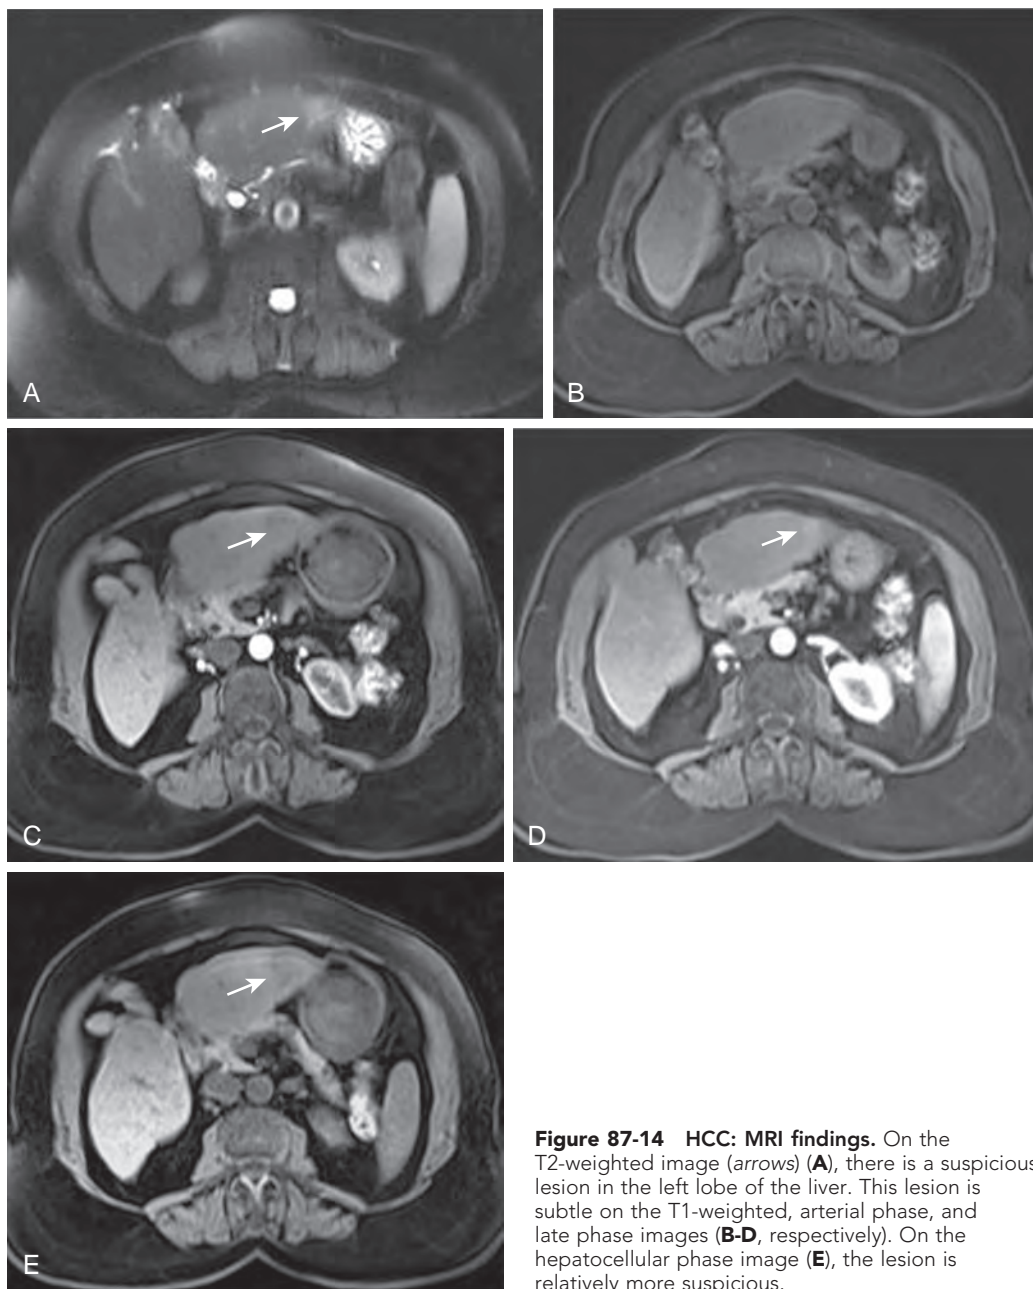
HCC: MRI findings. On the T2-weighted image (arrows) (A), there is a suspicious lesion in the left lobe of the liver. This lesion is subtle on the T1-weighted, arterial phase, and late phase images (B-D, respectively). On the hepatocellular phase image (E), the lesion is relatively more suspicious.
